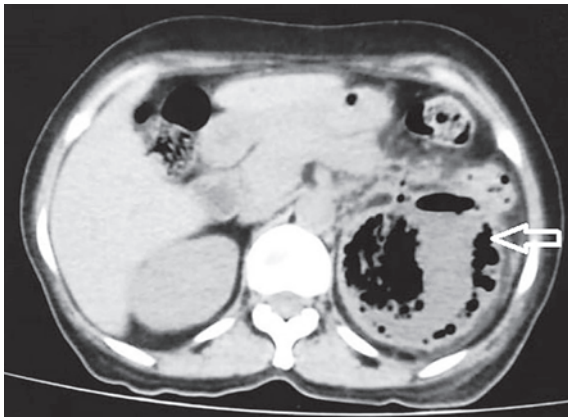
CT Abdomen-Air in the kidney (arrow) - emphysematous pyelonephritis
